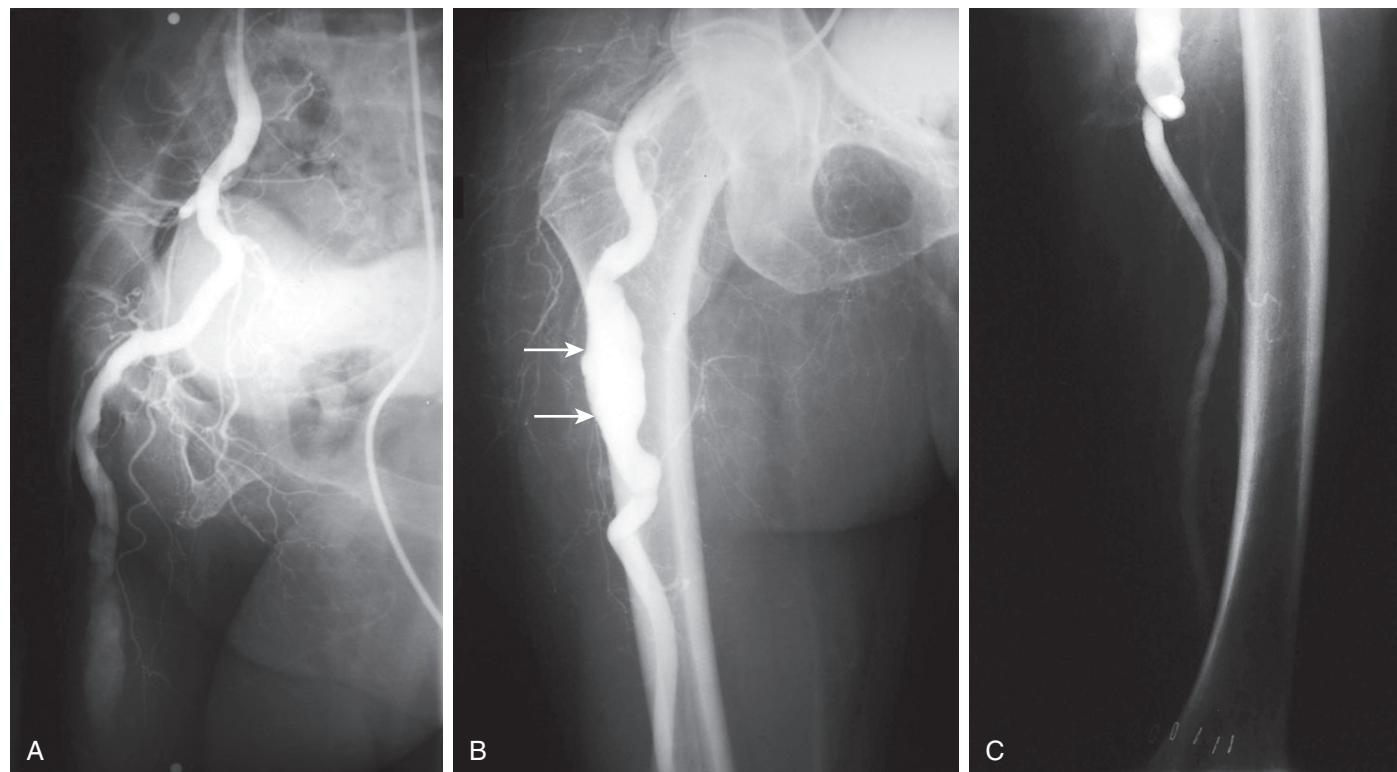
Persistent Sciatic Artery. (A) The sciatic artery in the pelvis is coursing posteriorly. (B) In the thigh, the sciatic artery has developed aneurysmal changes (arrows) and courses lateral to the normal location of the femoral artery. (C) More distally in the thigh, the sciatic artery is located laterally and ultimately joins the popliteal artery in the popliteal fossa (not seen on the radiograph).
